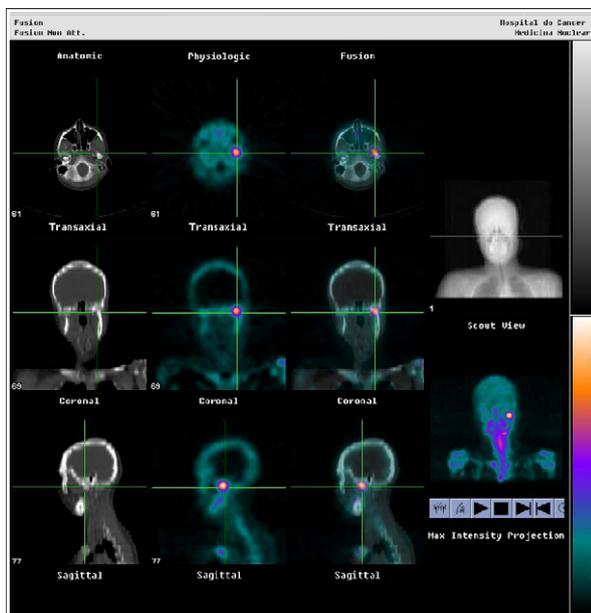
Coregistered fused images obtained by ^{99m}Tc-MDP SPECT/CT in the transverse, coronal, and sagittal planes, showing focal hyperconcentration of the radiopharmaceutical in the left TMJ (SPECT/CT and left TMJ).
